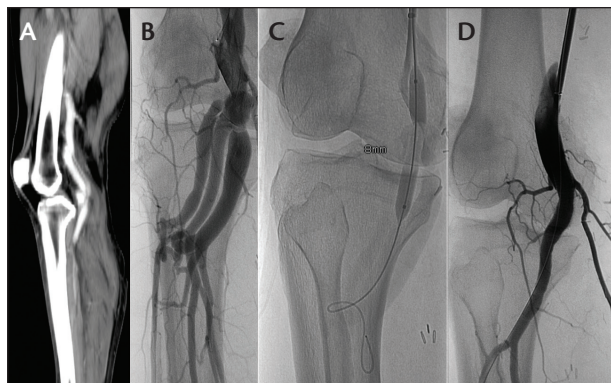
Sagittal CTA image showing a right popliteal pseudoaneurysm with arteriovenous fistula (A). An angiogram confirming voluminous popliteal pseudoaneurysm with direct contrast injection into the popliteal and femoral veins (B). Balloon occlusion test (C). A completion angiogram showing exclusion of the right popliteal pseudoaneurysm and the arteriovenous fistula while maintaining normal runoff of the vessels below the knee (D).
